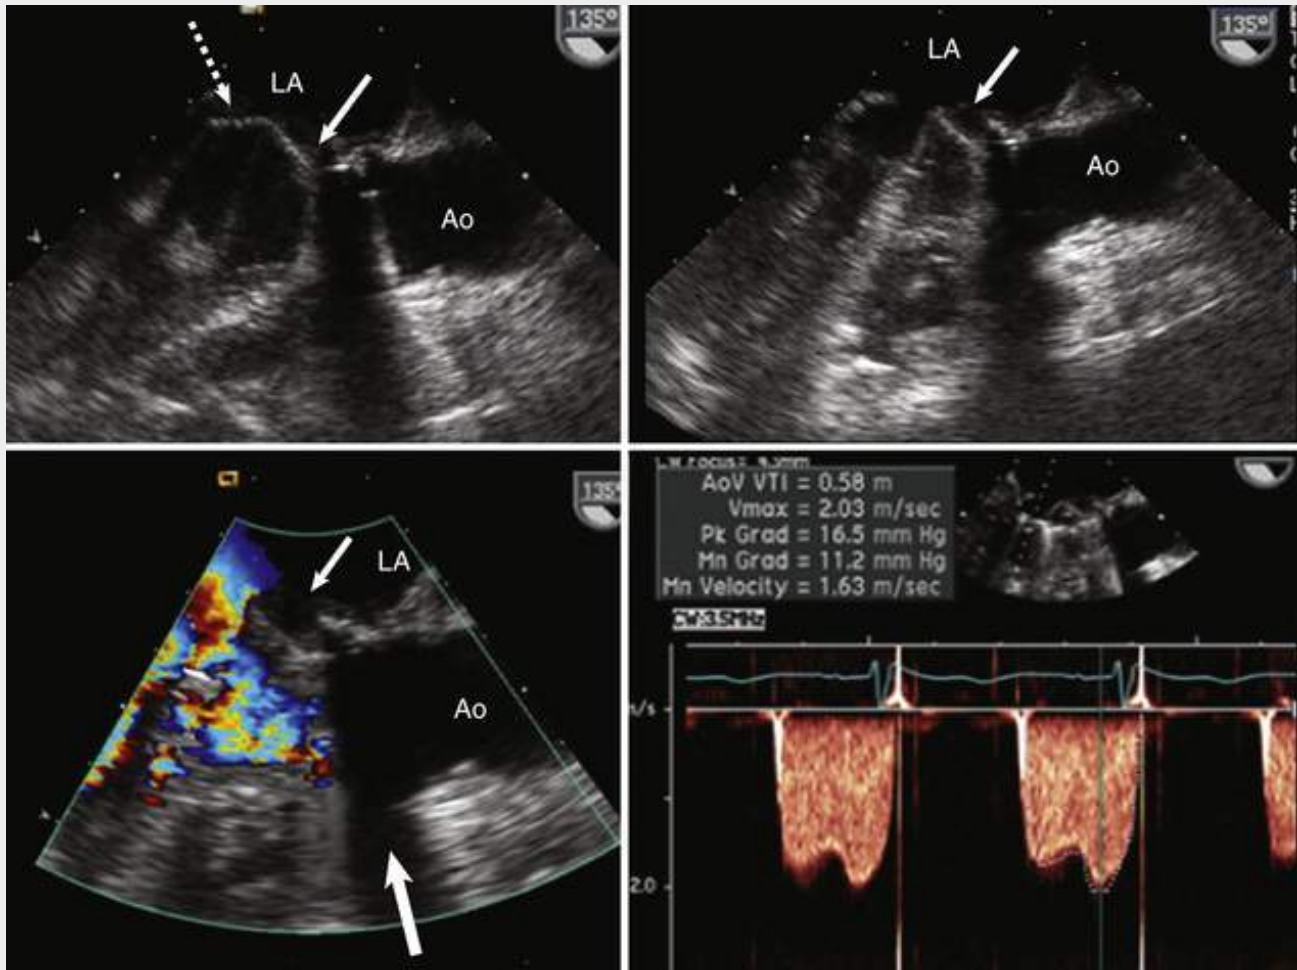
TEE showing a bileaflet mechanical mitral prosthesis in which one disc is immobilized because of thrombus. Upper left, Systolic frame showing that neither disc (*arrows*) closes completely. Upper right, While the left disc opens fully, the right disc is immobile. Lower left, Color flow Doppler demonstrating high-velocity flow through a single orifice. The *large arrow* indicates acoustic shadowing because of the mitral sewing ring. Lower right, Doppler demonstrating an elevated transmittal gradient (11 mm Hg at a heart rate of 65 beats/min). Ao, Aorta; LA, left atrium.
